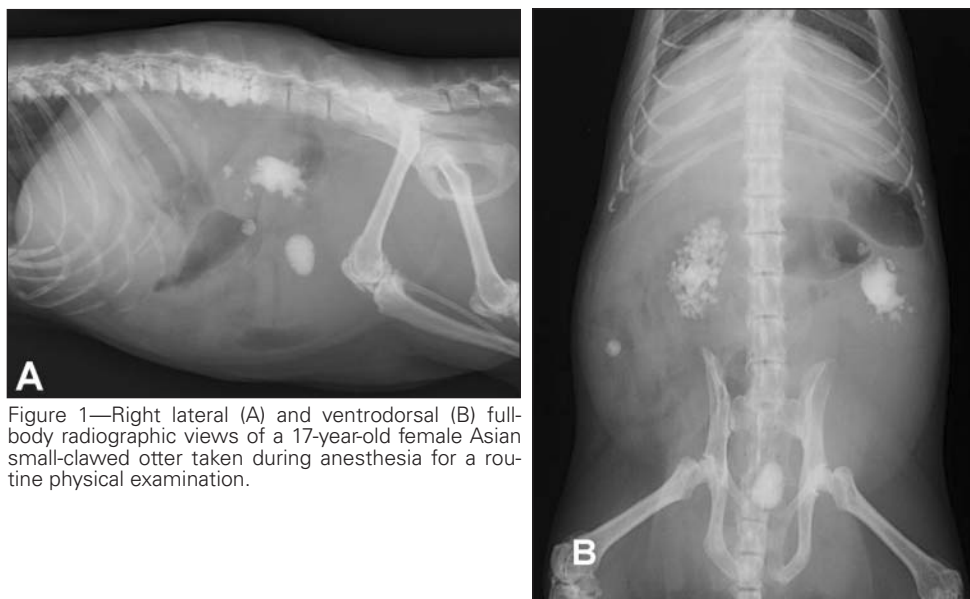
Right lateral (A) and ventrodorsal (B) full-body radiographic views of a 17-year-old female Asian small-clawed otter taken during anesthesia for a routine physical examination.
